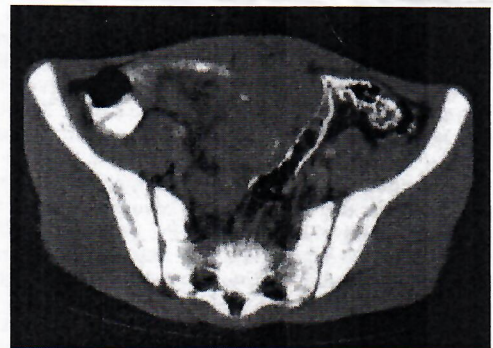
Tumor growing among intestinal loops (computed tomography scan).
